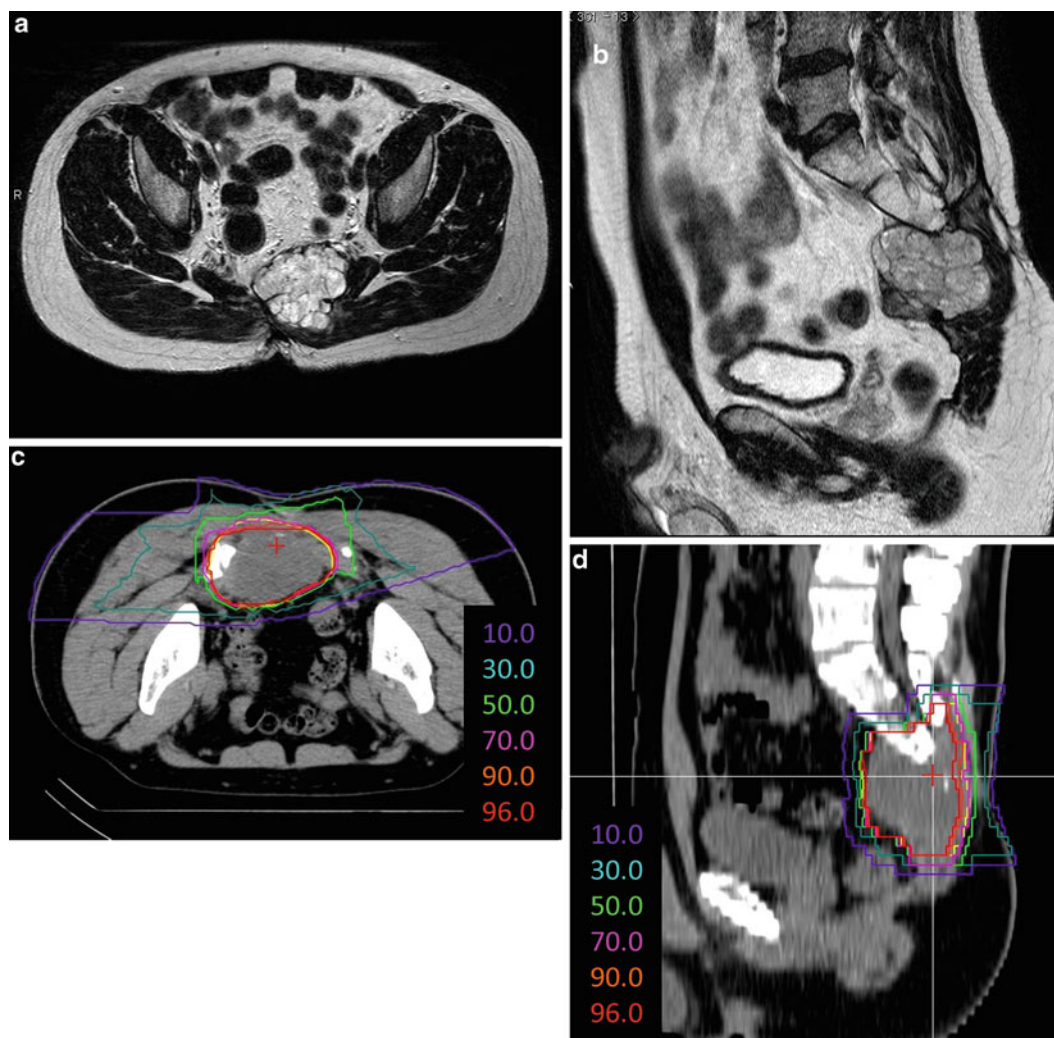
(a) Axial and (b) sagittal T2-weighted magnetic resonance images obtained before carbon ion radiotherapy. Representative (c) axial and (d) sagittal isodose distributions
